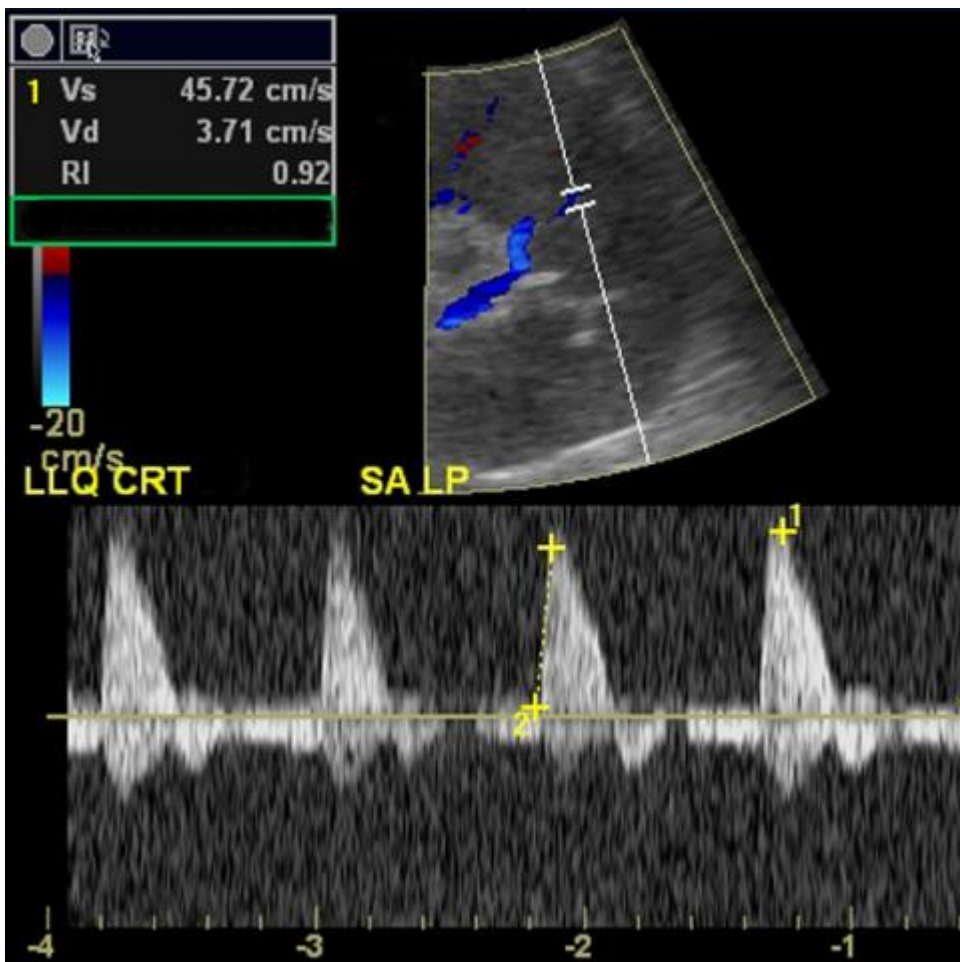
Acute tubular necrosis. Spectral Doppler image of a segmental artery reveals an increased resistive index, a non-specific finding which was due to acute tubular necrosis in this case.
